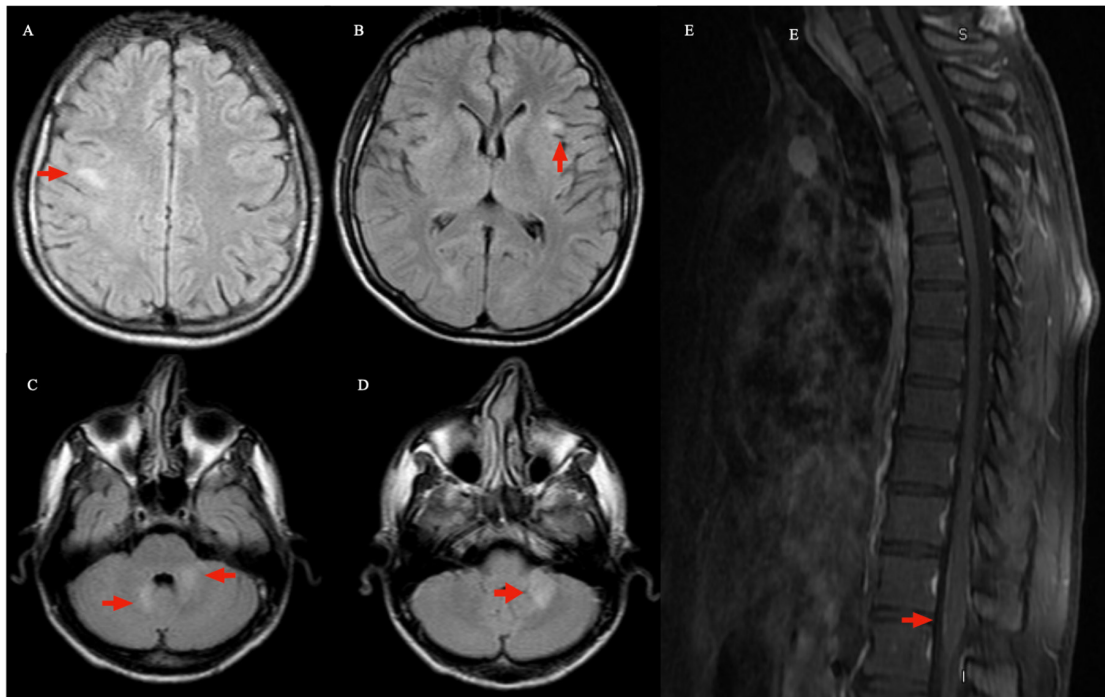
A, B) Fluid attenuated inversion recovery (FLAIR) axial image from the first admission. Bilateral subcortical FLAIR hyperintense lesions (lower left). C, D) High signal intensity lesions in both cerebellar peduncles (upper left). E) T2 hyperintense longitudinally extending conus medullaris lesion with gadolinium enhancement on T1-weighted MRI (right)
